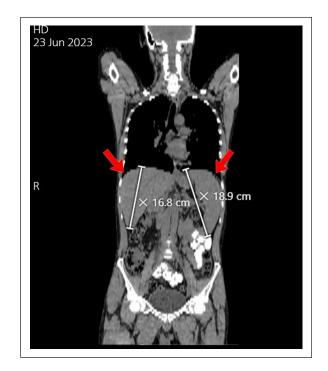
Whole body CT scan without contrast showed hepatomegaly approximately 16.8 cm (normal craniocaudal length 10–12.5 cm) and massive splenomegaly approximately 18.9 cm (normal length less than 12 cm).
